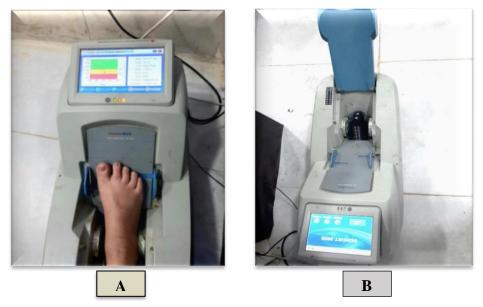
(A) QUS was the measurement of osteoporosis at the heel of the right foot, (B) Quantitative ultrasound device calibration.
